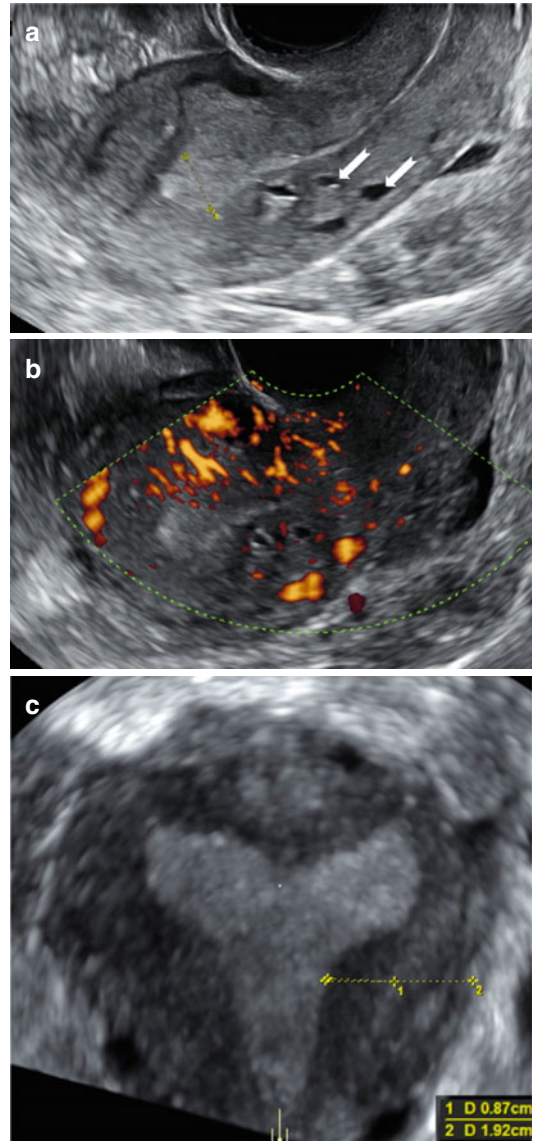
Ultrasound images of a uterus in a 25 year old woman with cystic areas only in the posterior wall (white arrows). Gray scale image (a) and Power Doppler image (b) showing diffusely spread small vessels surrounding the cystic areas. Coronal section (c) obtained by 3D ultrasound of the same uterus showing a thickened JZ
